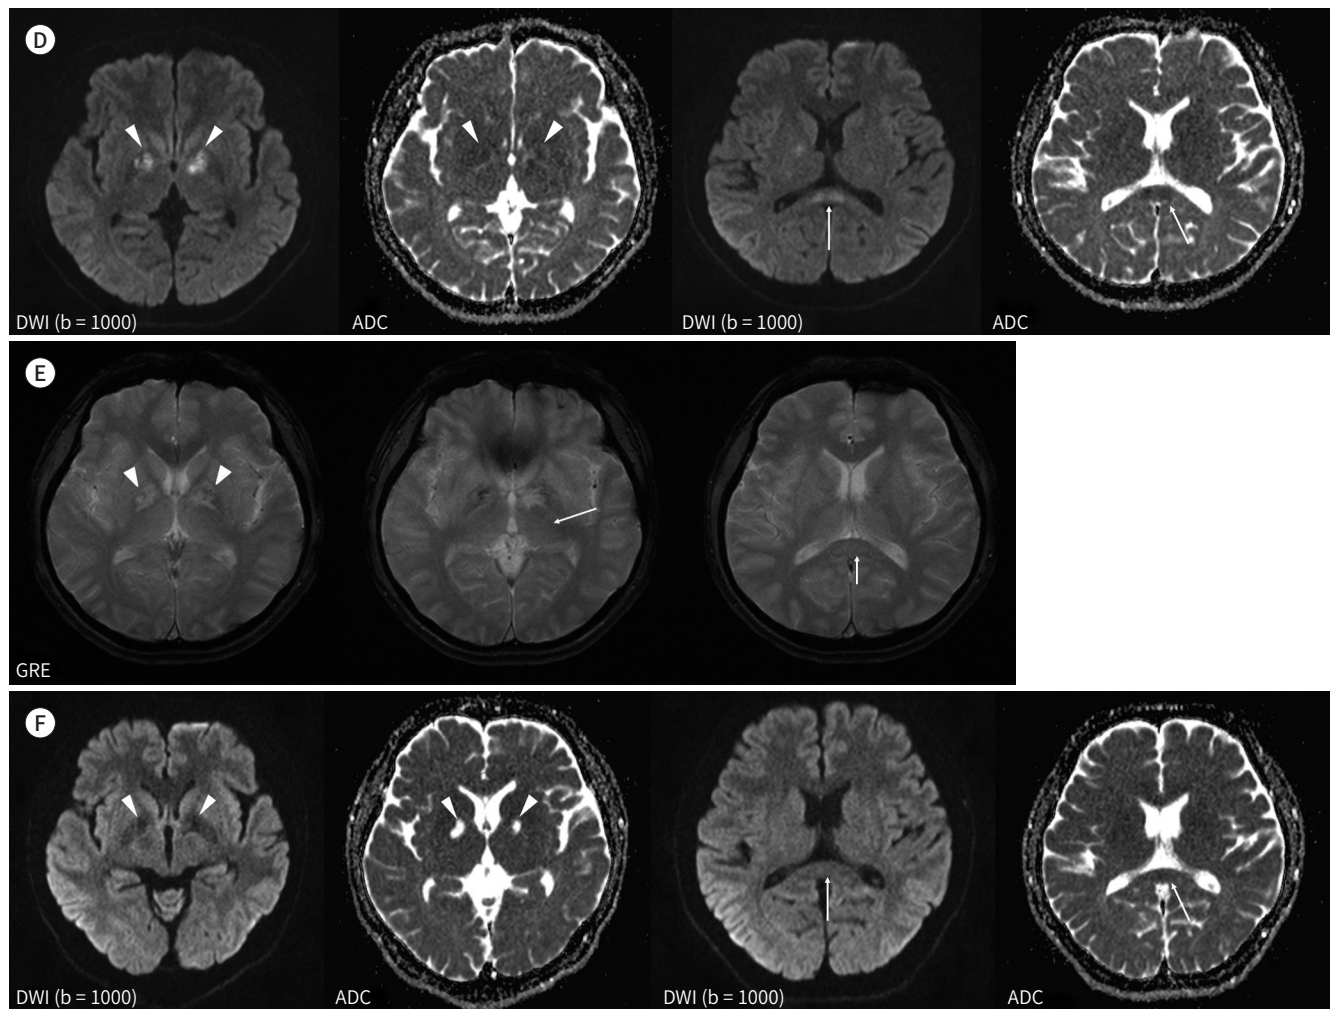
CT and MRI findings of a 38-year-old man with general weakness and urinary incontinence after climbing a 5000-m-high mountain.
